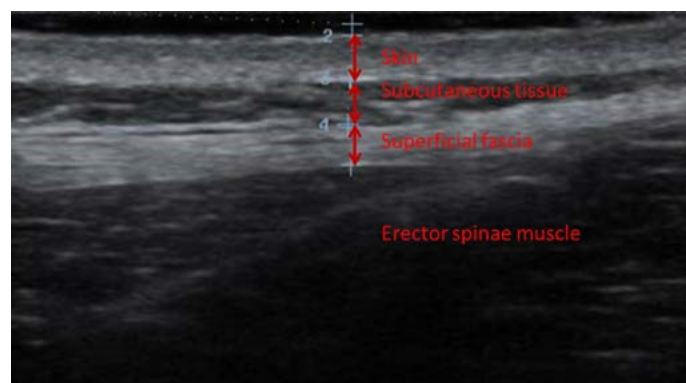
US measurements of skin, subcutaneous tissue, and superficial fascia thickness. Abbreviations: US, ultrasonography.
